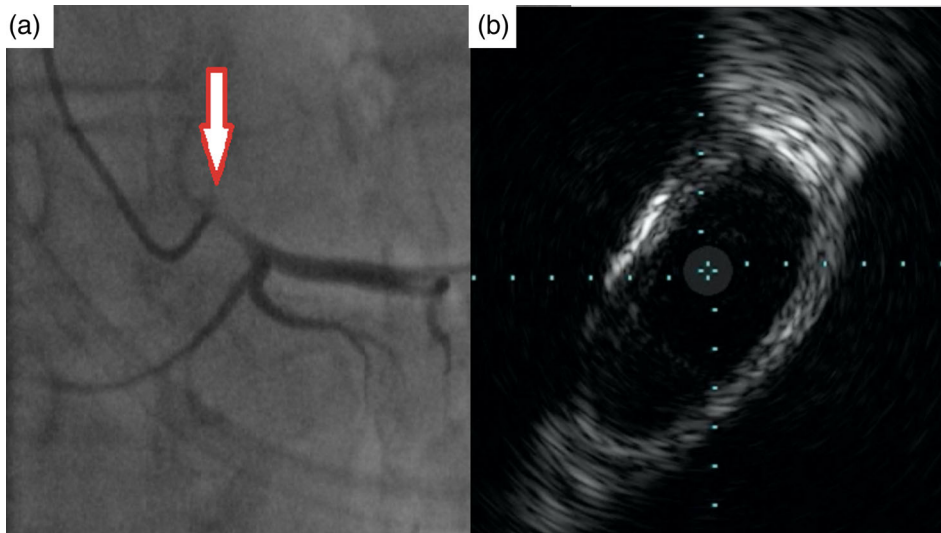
Coronary angiography (a) demonstrates LMCA compression (red arrow) in the setting of a dilated PA with ostial narrowing and smooth post-obstructive reconstitution of the vessel. Cross-sectional intravascular ultrasound view (b) of LMCA compression with evidence of an asymmetric oval-shaped lumen and no sign of atherosclerosis. LMCA, left main coronary artery; PA, pulmonary artery [Color figure can be viewed at wileyonlinelibrary.com]
